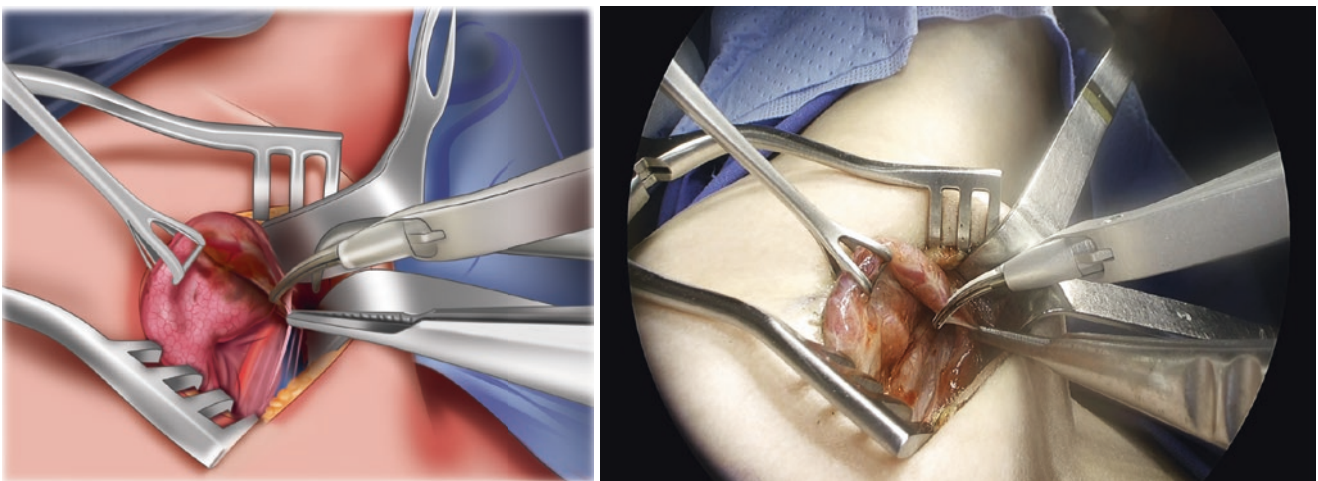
Control of the superior vascular pedicle. Blunt dissection of the superior vascular pedicle is performed. Hemostasis and section of the superior thyroid vessels is achieved using the ultrasonic energy device
